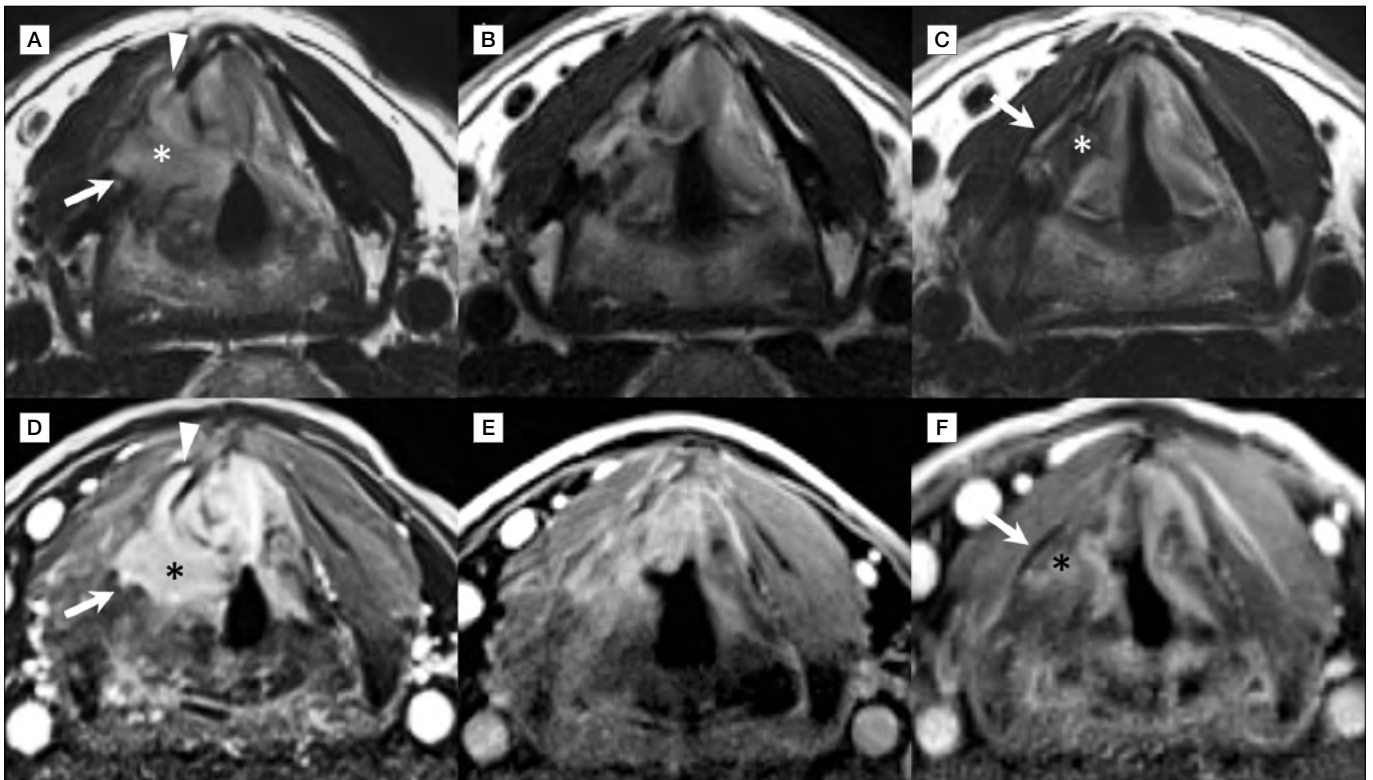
Chondritis evolution in patient No. 1. Axial T2-weighted (A, B, C) and contrast-enhanced fat-saturated T1 (VIBE) (D, E, F) images. Post-CO₂ TOLMS larynx MR (A, D) shows a lesion centred in the right paraglottic space deep to the middle and anterior thirds of the false vocal cord (asterisk) with bulging of the mucosa and consequent reduction of the airway. The lesion shows focal extension through the full thickness of the thyroid lamina (arrow) and along its external perichondral surface (arrowhead). It is characterized by T2-weighted hyperintense signal and intense homogenous contrast enhancement. At one month follow-up (B, E), there was reduction of the extension of the lesion and decreased contrast enhancement. At 6 months follow-up (C, F), there was near-complete resolution of the LC process. An area of T2 low signal (scar tissue) with subtle contrast enhancement is now visible in the paraglottic space (asterisk) and the thyroid lamina appears as newly ossified (arrow).
